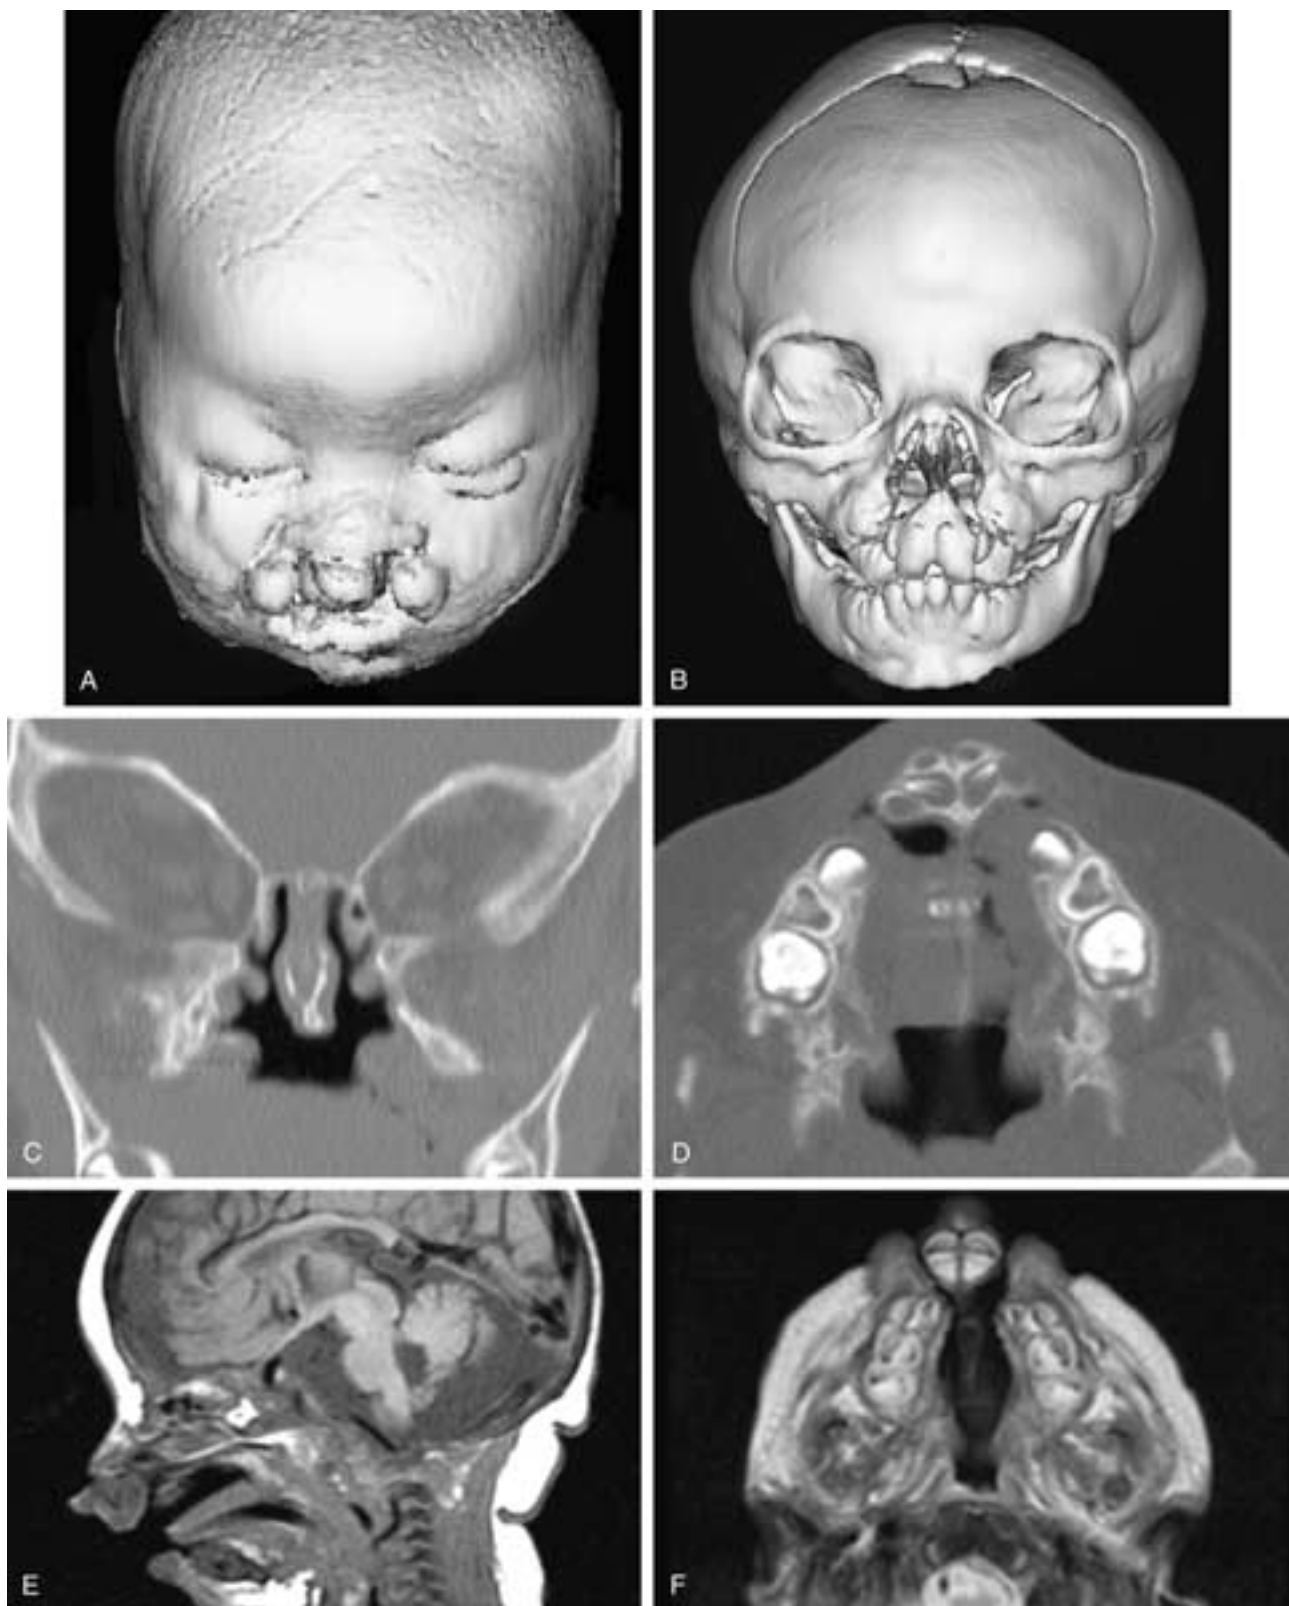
Bilateral cleft lip and palate in a 2-month-old boy. A, Three-dimensional CT of the skin surface. B, Three-dimensional CT of bone surface. C, Coronal CT. D, Axial CT. E, Sagittal T1 MRI. F, Axial T2 MRI. The symmetric clefts extend through the lips, the bases of the nostrils, the alveolar ridges, and the palate, leaving a distorted premaxillary segment with the central prolabium isolated from the paired maxillary processes. The prominent central incisors and smaller lateral incisors are positioned far anterior to the maxillary arches. The clefts course obliquely from anterolateral to posteromedial between the primary and secondary palates (cf. Fig. 1-5) before continuing directly posteriorly between the two maxillary palatal shelves to either side of the ununited septum.
